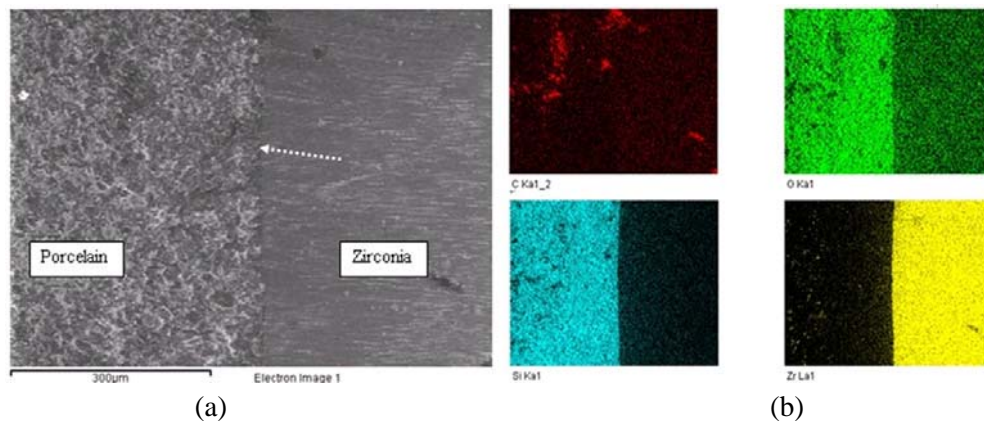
ESEM image and corresponding elemental X-ray maps of the region of interfacial bonding
